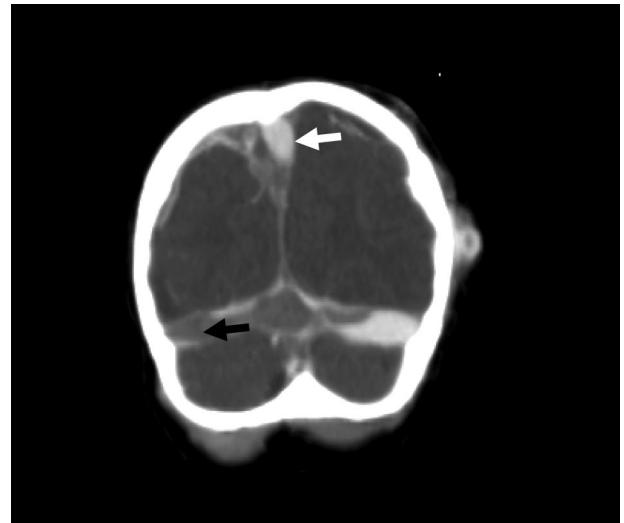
Computed tomographic venogram showing mixed density within venous sinuses (high-density contrast in patent segments (white arrow) and low density (black arrow) in nonperfusing thrombosed segments).
